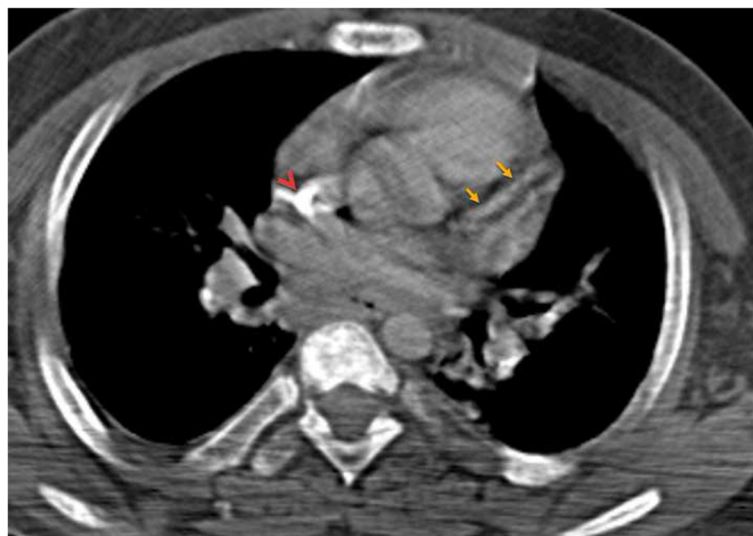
The un-enhanced chest CT image obtained 3 years ago shows a chronic calcified thrombus (arrowhead) in the superior vena cava. Left anterior descending (LAD) coronary artery (arrows) is normal, and no calcific atherosclerotic plaque is seen
